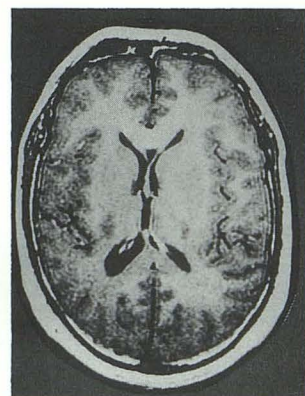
Axial postcontrast-enhanced MR image (600/30) using Gd-DTPA reveals no enhanced tumor mass.
